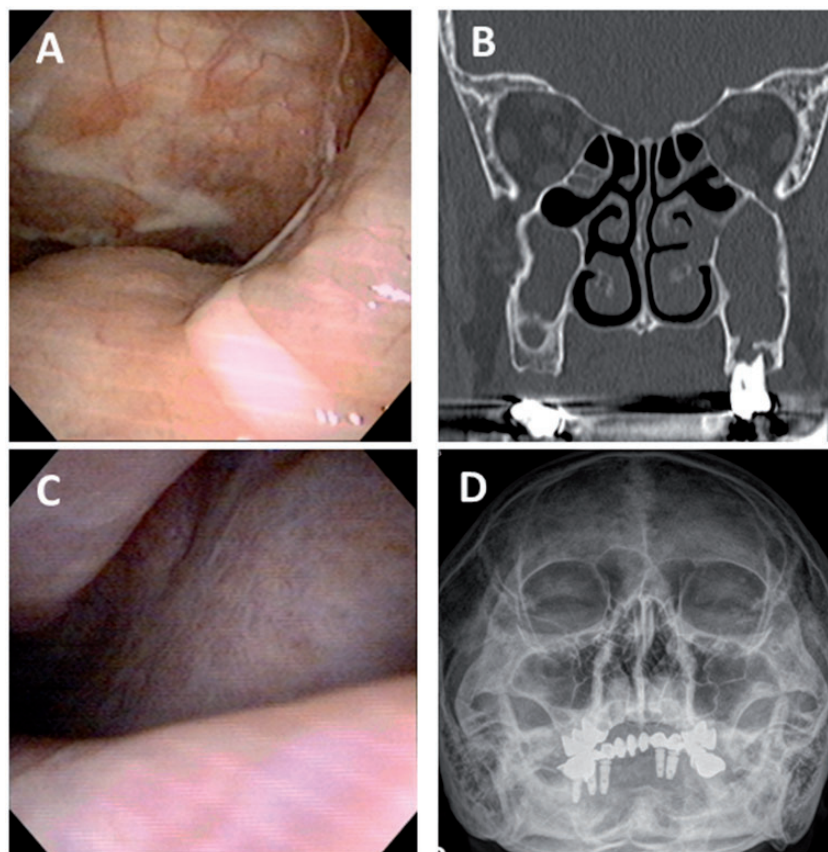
Representative CT, X-ray, and endoscopy findings of the odontogenic sinusitis cured by dental extraction. (A) Purulent drainage from the left maxillary sinus into the nasopharynx before treatment. (B) Periapical abscess and defect of the left maxillary floor before treatment. (C) No discharge after treatment. (D) Clear maxillary sinus after treatment.
